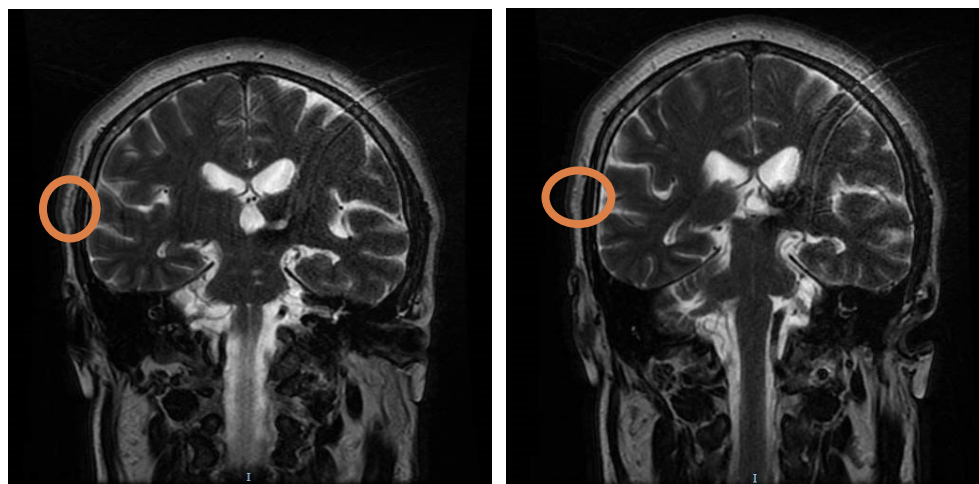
MRI aspect after 3 month from acute stroke
